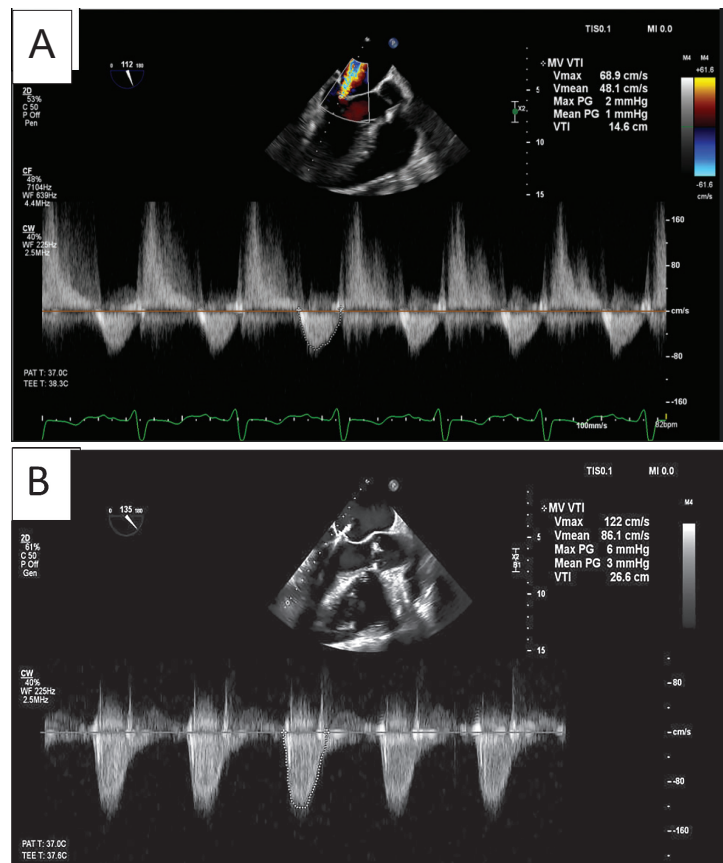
Transoesophageal echocardiography with cw Doppler examination across the mitral valve before and after transcatheter edge-to-edge repair. A. Preprocedural assessment demonstrated low mitral valve gradients, with a maximum pressure gradient (PG) of 2 mmHg and a mean PG of 1 mmHg. B. Postprocedural examination revealed increased mitral flow velocities (Vmax 122 cm/s) with a mild rise in mean gradient (to 3 mmHg), without evidence of clinically significant iatrogenic mitral stenosis
